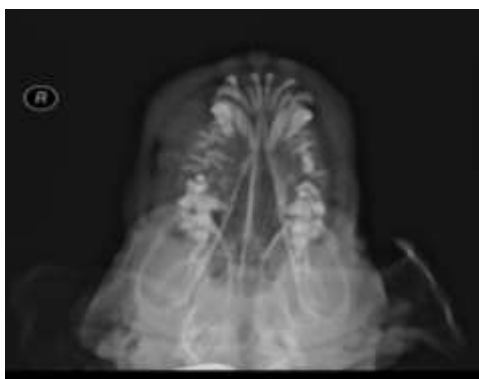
Radiograph showing reduced bone density and soft tissue swelling of maxilla and mandible
